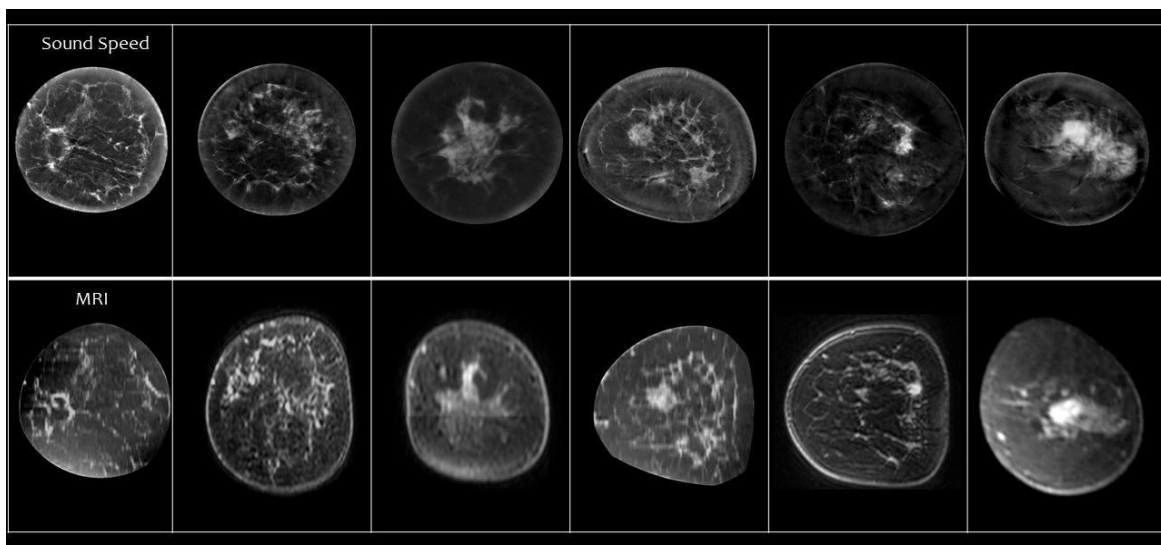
Top: Coronal UST sound speed images for 6 different patients. Bottom: Corresponding fat subtracted contrast enhanced MR images.
